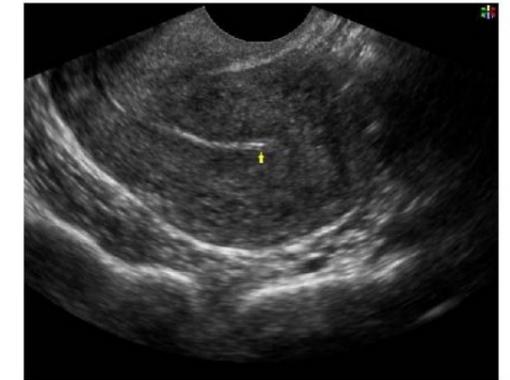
Ultrasound image indicating endometrial recovery (arrow).
